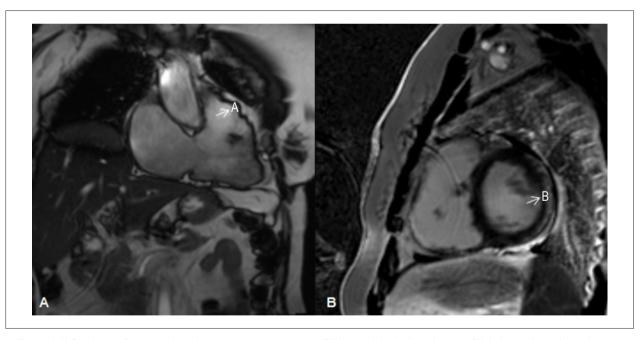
A) Steady-state free precession cine magnetic resonance imaging (RV long axis view) indicated regional RV dyskinesia (arrows) at end-systole.
